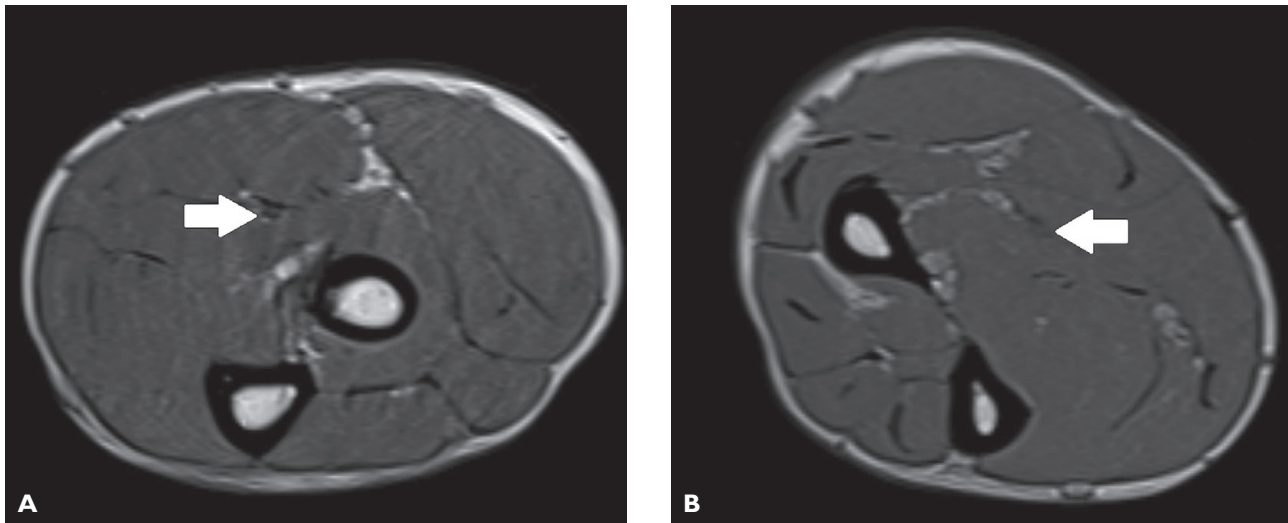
A) Magnetic resonance imaging of the right forearm demonstrating the usual-looking median nerve (white arrow). B) Magnetic resonance imaging of the left forearm demonstrating flattening of the median nerve between the muscle bellies of the humeral and ulnar heads of the pronator teres (white arrow).
